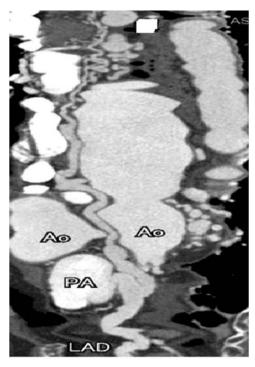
Chest CT scan of the patient showing anomalous origin of the left coronary artery from the pulmonary artery along with an aneurysm of the LCA.
